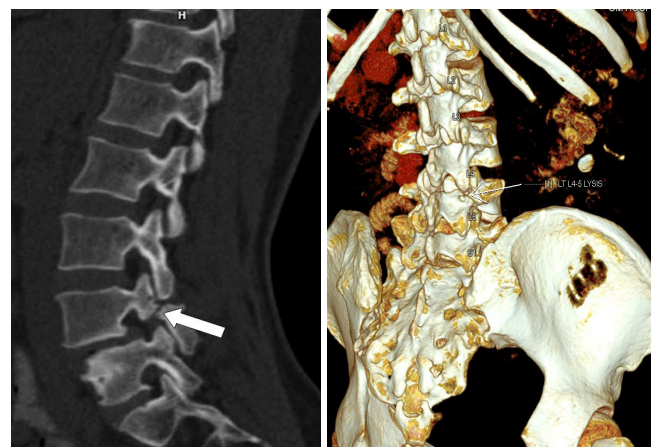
a) Sagittal CT image of L4-5 spondylolysis (arrow) b) 3D CT Oblique view of left sided L4-5 spondylolysis (arrow)
